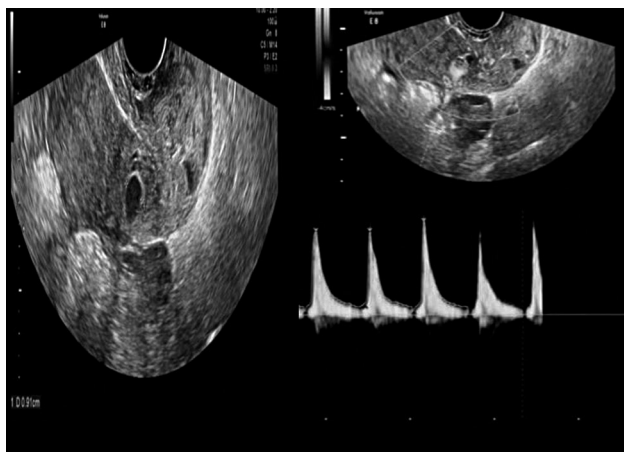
Left picture is a gray scale ultrasound showing the anechoic area, measuring 8×8 mm. Right picture is a color Doppler ultrasound showing an area with swirling blood flowing with arterial waveforms.
